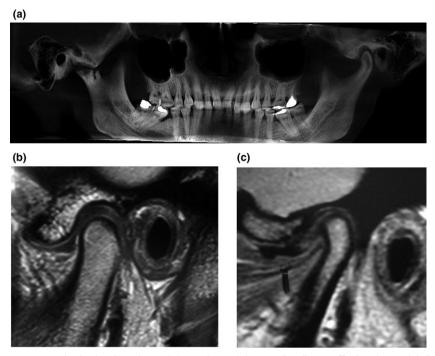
(a) A digital orthopantomogram clearly showing advanced destructive and degenerative disease affecting the condyle in the left side of the image and a normal condyle on the right side of the image. (b) A pair of MRI's of the TMJ showing a normal joint on the left and a joint showing severe internal derangement on the right, (c) consisting of a severely displaced and deformed disc that is non-reducing which has resulted in the clinical presentation of chronic closed lock of the jaw.
